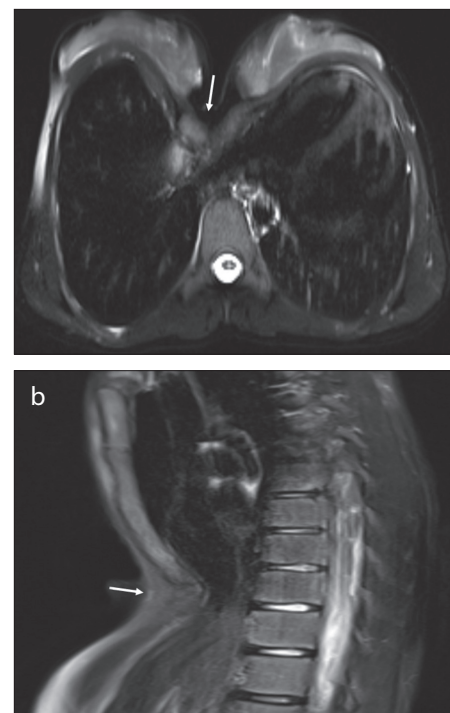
a, b. A 14-year-old female with pectus excavatum. Axial T2-weighted (a) and sagittal T2-weighted (b) images reveal the pectus excavatum deformity (white arrows).
